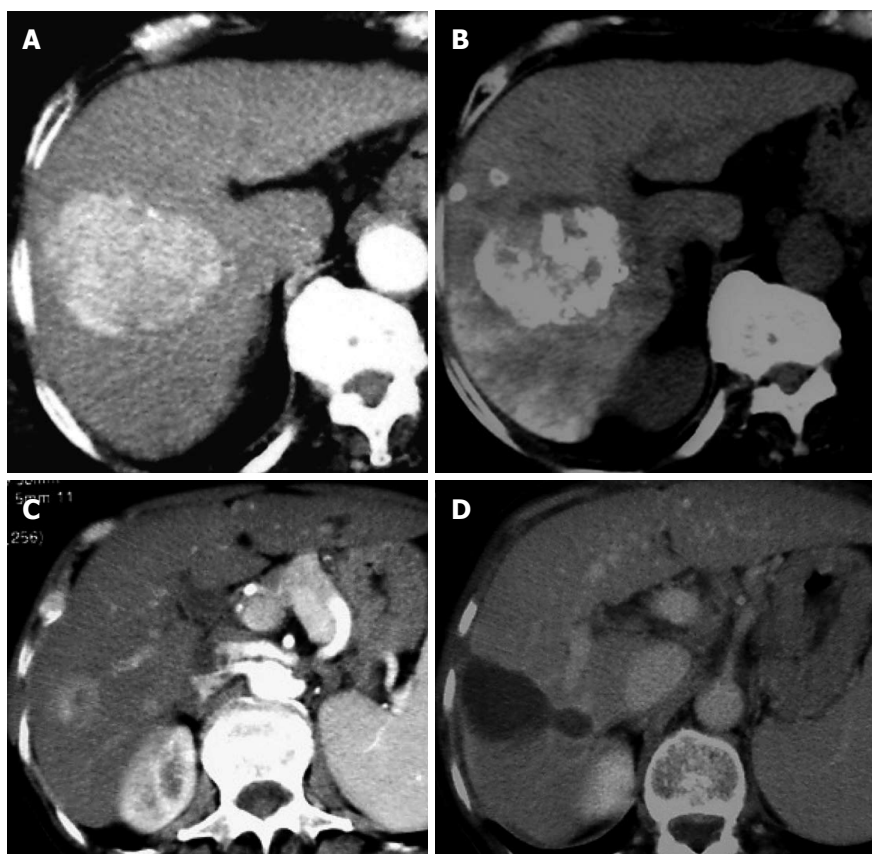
Computed tomography scan. A: An intermediate hepatocellular cancer (HCC) is showed at liver segment VII before transarterial chemoembolization (TACE). Note the HCC hyperdensity in arterial phase; B: The same tumor showed in A was observed 1 mo after TACE. Note the lipiodol impregnation of the tumor in computed tomography scan without intravenous contrast; C: An early hepatocellular cancer is showed at liver segment V before radiofrequency ablation (RFA). Note the HCC hyperdensity in arterial phase; D: The same tumor showed in C was observed 1 mo after RFA. Note the cavitation of the tumor as an image with no density.
